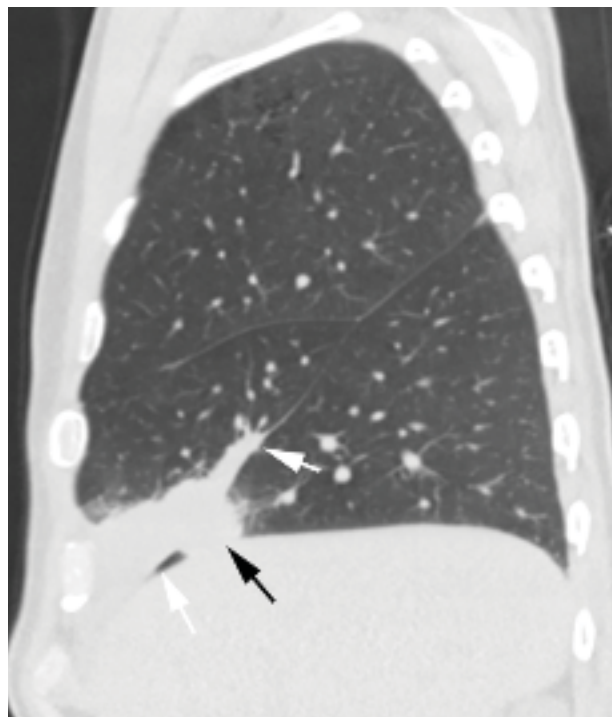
Invasion across fissures. Sagittal reconstruction from an unenhanced CT scan demonstrates a focal area of consolidation (black arrow) in the right middle lobe that has invaded across the major fissure (white arrows) into the right lower lobe.
